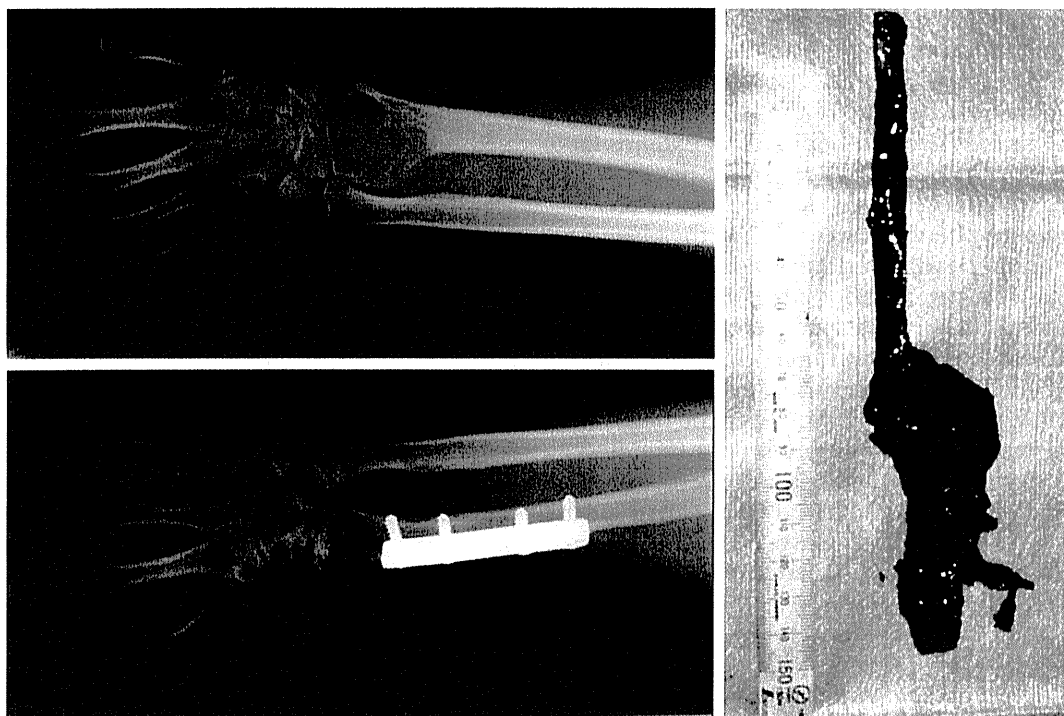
Patient 5, a 28-year-old man, presented with a giant cell tumor of the distal radius. (*Above, left*) Preoperative radiograph shows a $48 \times 38 \times 35$ -mm tumor. (*Right*) Harvested 7-cm-long vascularized fibula head graft. (*Below, left*) Radiograph obtained 3 years postoperatively shows good ossification between the transferred bone and the residual bone.
